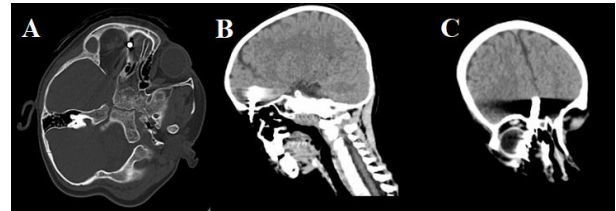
The axial (A), sagittal (B) and coronal (C) CT tomograms demonstrate a metallic foreign body, penetrating the medial wall of the right orbit and partially through the roof of the ipsilateral orbit, with the metal tip extending along the cerebral falx. The brain parenchyma was without evident and detectable injury.
